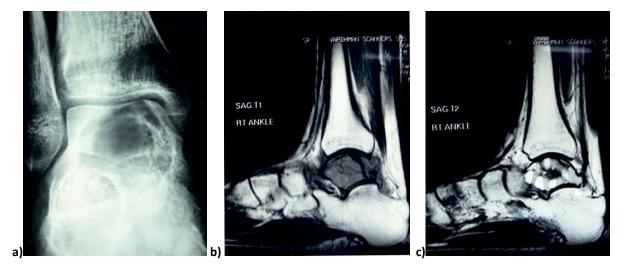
a) Plain radiograph of right ankle in AP view shows lytic lesion without cortical break in talus.
